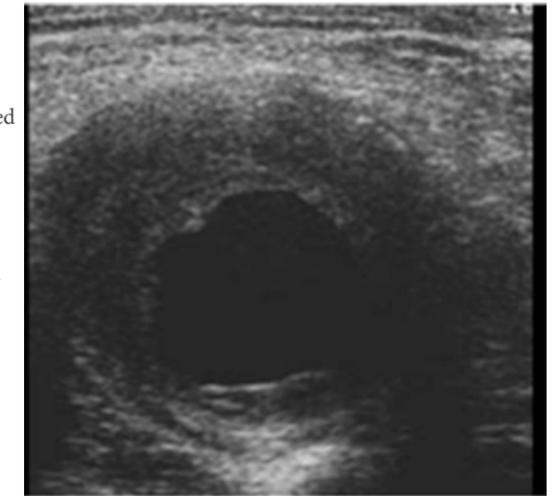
ultrasonographic evidence of pseudoaneurysm
